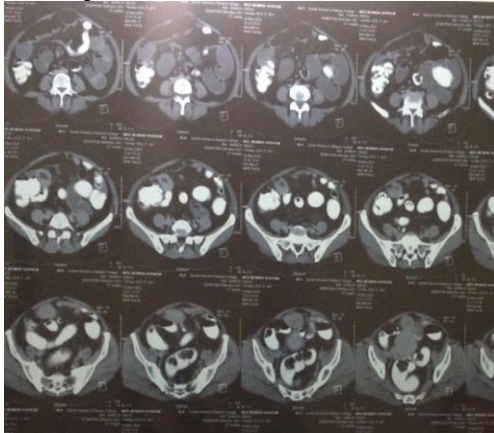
CT scan film of multiple axial section showing dilated small bowel loops with small bowel intussusception.
